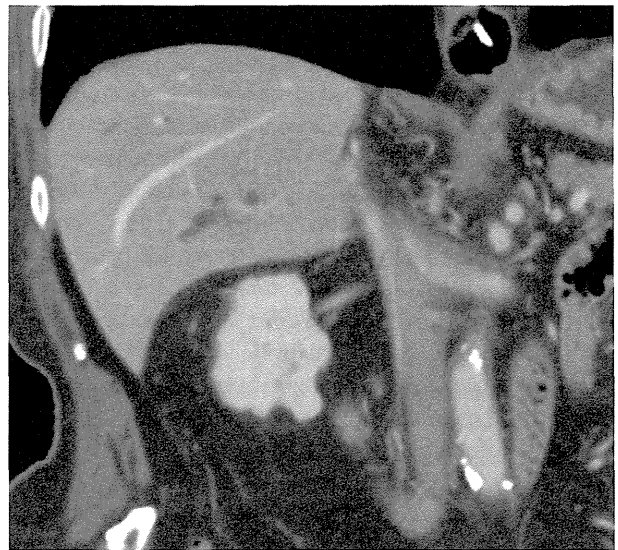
Coronal image of contrast-enhanced computed tomography obtained 20 days after portal vein embolization shows sufficiently thrombosed right portal branches without right hepatic vein embolization
